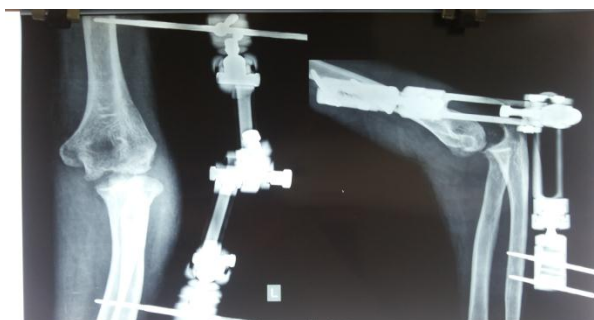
Anteroposterior and lateral radiograph showing the LRS in situ
